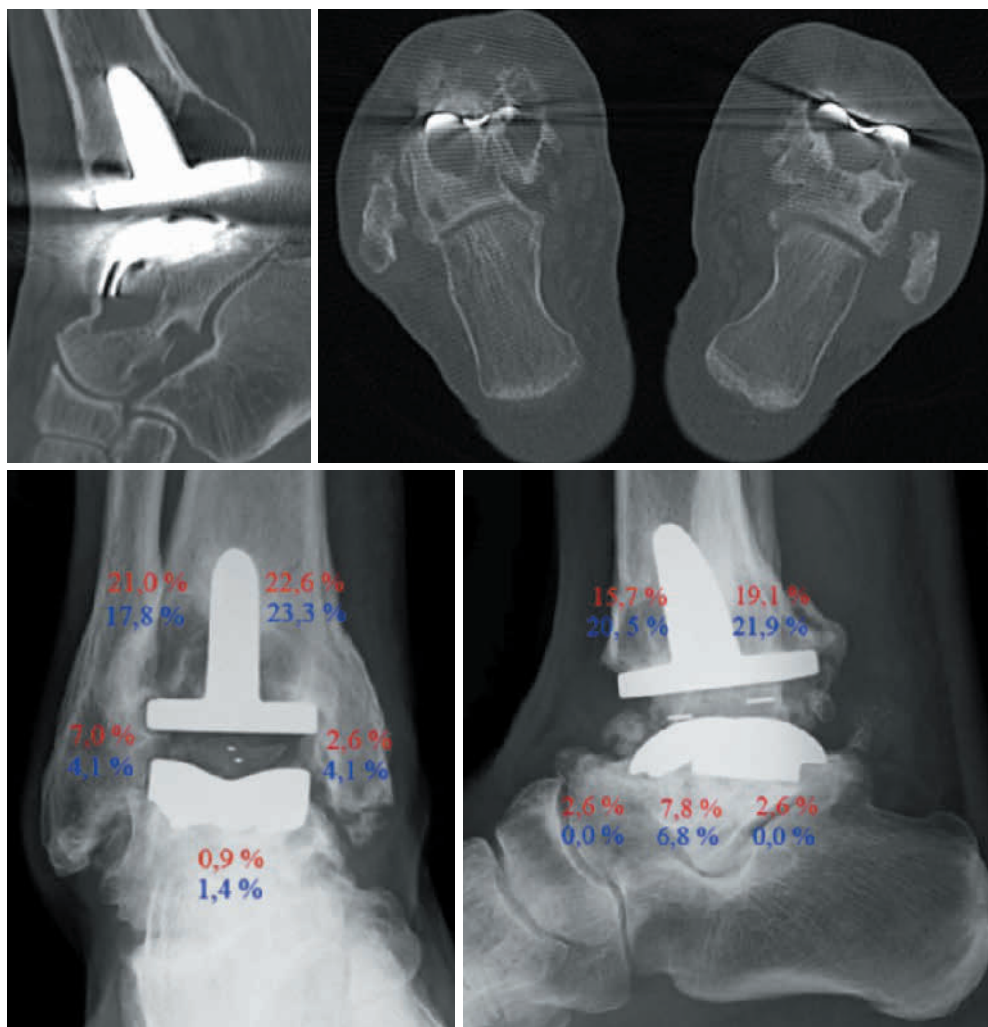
Examples of osteolytic lesions in CT scans and plain radiographs and distribution of lesions in plain radiographs in Study I (red: all lesions, blue: marked lesions)
